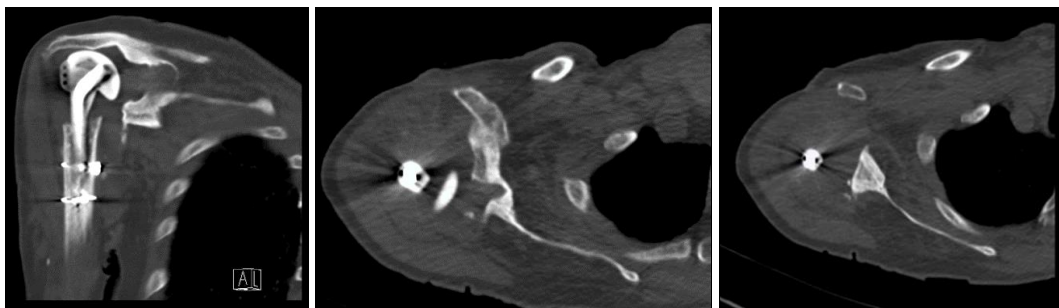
CT highlighting glenoid bone loss following 1st stage revision.
